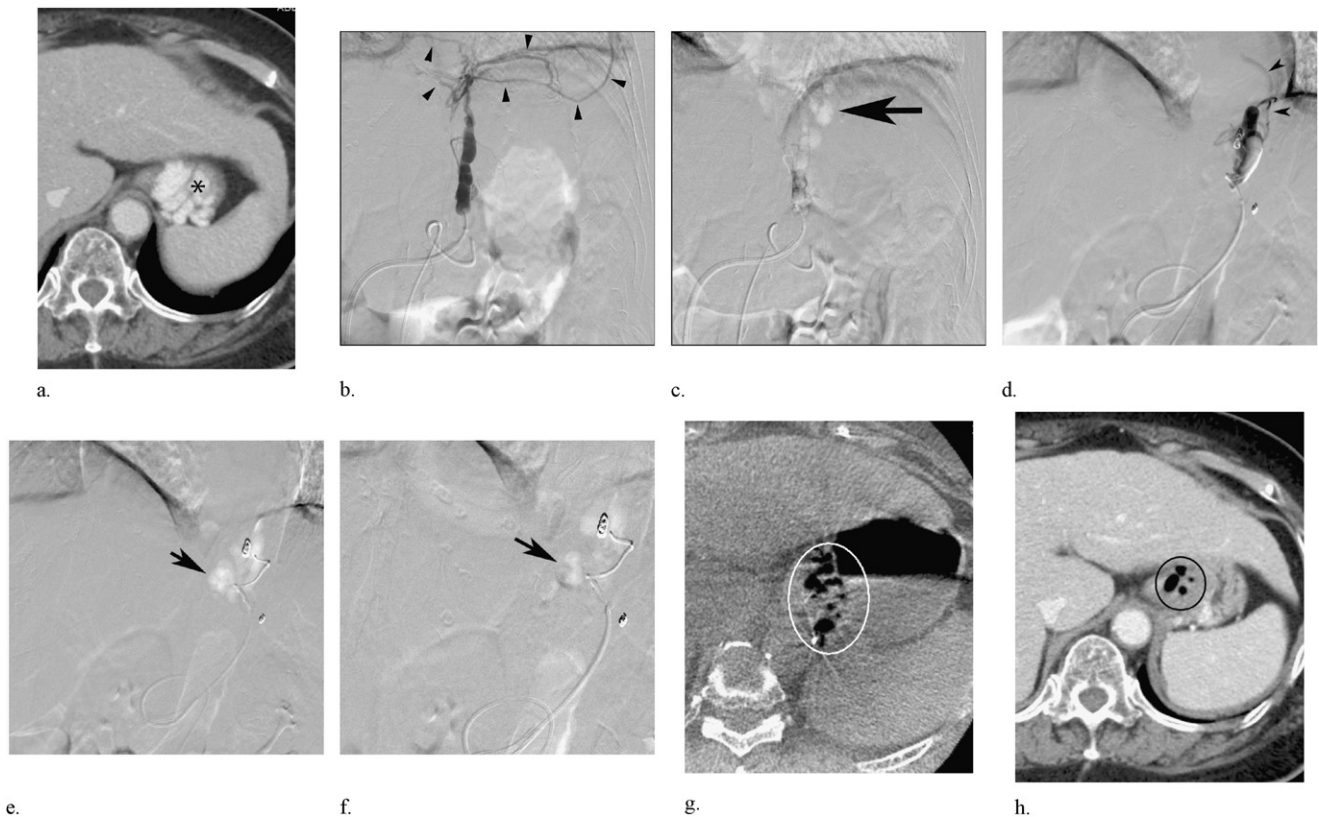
Patient 5. After contrast CT (a) and before balloon-occluded retrograde transvenous obliteration (BRTO), the target gastric varices (GV) (*) are revealed projecting into the gastric lumen. The first balloon-occluded retrograde transvenous venography (BRTV) at the orifice of the gastrorenal shunt using iodine (b) does not demonstrate the GV (grade 4) because of rich collaterals (arrowheads), whereas CO₂ BRTV (c) partially demonstrates the GV (arrow) and is graded as a 3. After advancing a microcatheter deeply into the gastrorenal shunt and coil embolization of the collateral, BRTV in the right lateral decubitus position using iodine (d) does not show the GV with remnant collaterals (arrowheads) and is graded as a 4, whereas CO₂ BRTV (e) opacifies the entire GV (arrow) and is graded as a 1. BRTO using foam polidocanol under digital subtraction angiography (f) is also graded as a 1, and C-arm CT confirms that foam stays in the GV (g) (circle) without collateral filling. Postcontrast CT 1 week after BRTO (h) demonstrates totally thrombosed GV (circle) including a small amount of gas.
